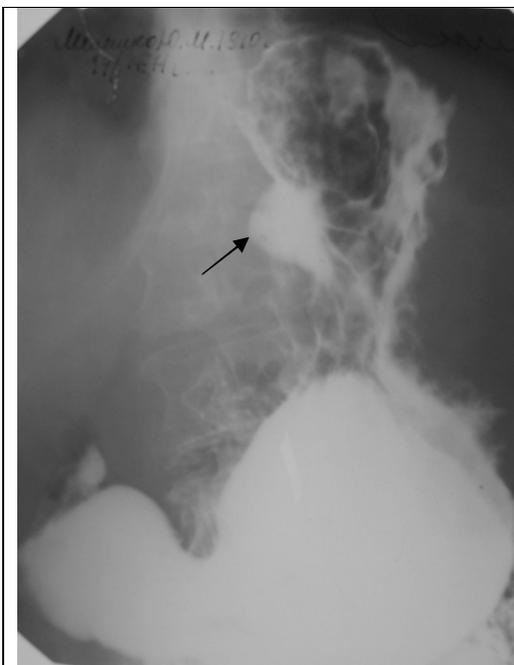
Radiograph of stomach in direct projection with barium sulphate contrasting. On the lesser curvature a big niche is identified (arrow) in the top third of stomach with convergence of folds of mucous membrane. Gastric ulcer.
